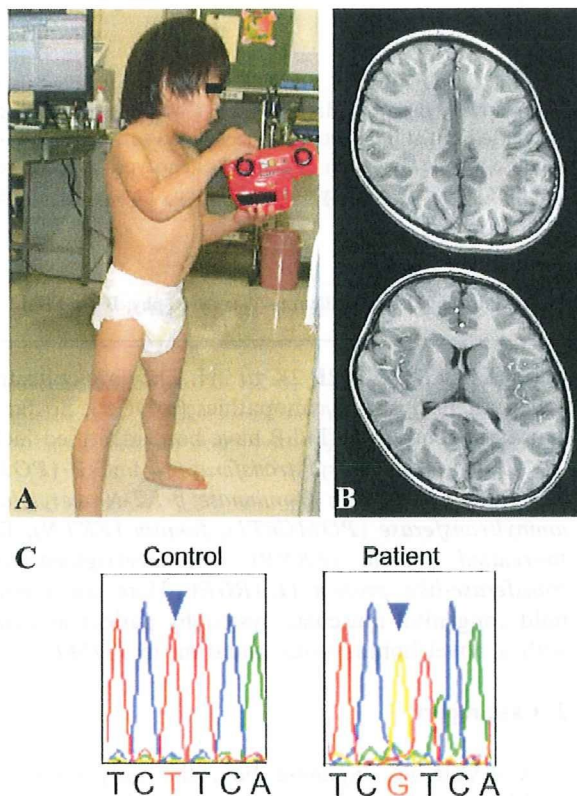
(A) The patient can stand and walk with no support. Minimal calf hypertrophy is seen. (B) T2 weighted brain magnetic resonance imaging shows no obvious brain anomaly, cortical dysplasia, or white matter changes. (C) Sequence analysis of *POMT2* revealed a homozygous mutation at c.604T > G in exon 5.
